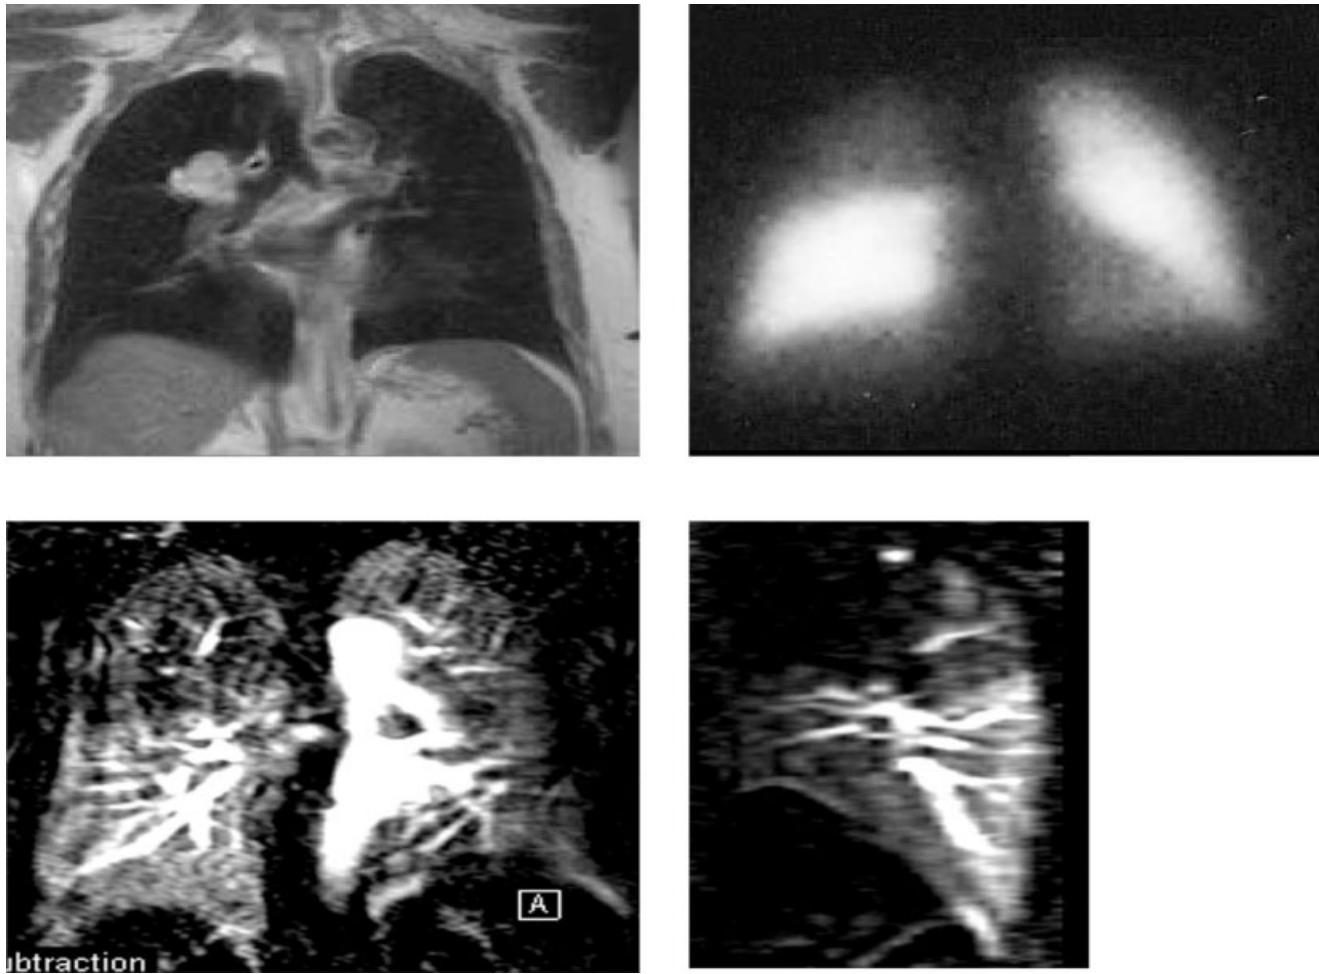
Three-dimensional perfusion MRI with parallel imaging techniques in a patient with a central lung cancer. Left top: Coronal HASTE. Right top: Conventional planar radionuclide perfusion scintigraphy. Bottom: Coronal and sagittal three-dimensional perfusion MR images. A perfusion defect due to the bronchus carcinoma is demonstrated.
